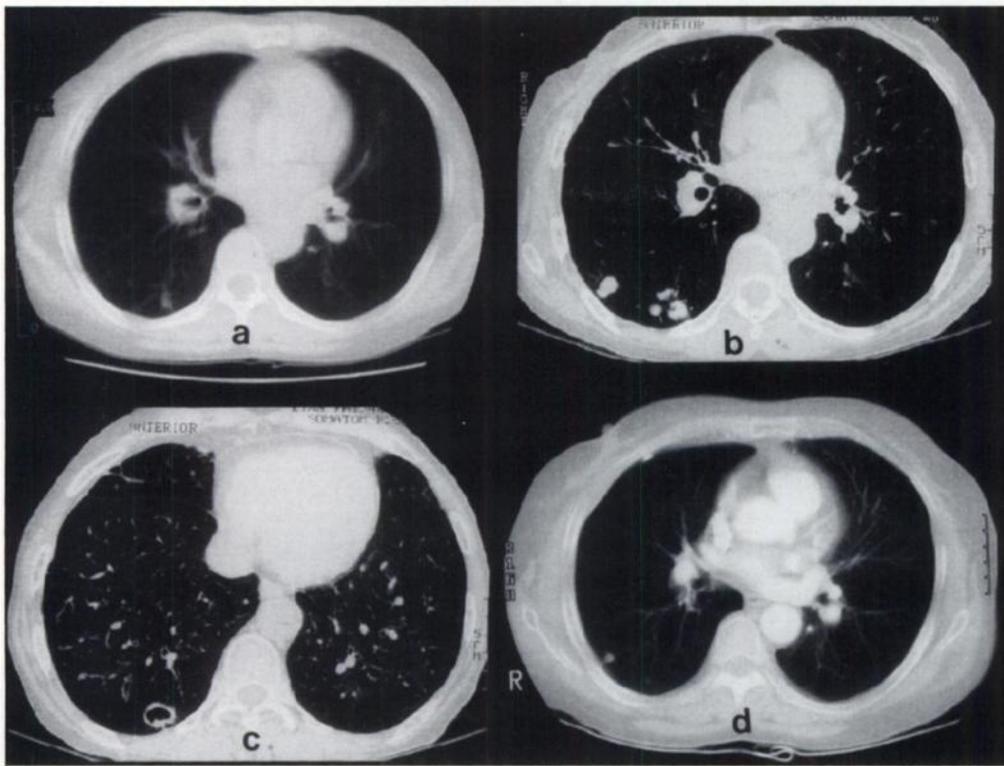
(A) Initial chest CT scan showing a small nodule in the lower lobe of the right lung. (B) A follow-up CT scan of the chest, 1 yr later, showing an increase in the number and size of the pulmonary nodules as well as cavitation (C). (D) Scan of chest 7 mo after steroid treatment showing considerable resolution of pulmonary nodules.
